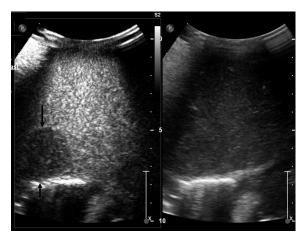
Metastasis of neuroblastoma using contrast-enhanced ultrasound with SonoVue. The malignant nature of the tumor is shown by portal venous hypoenhancement.
